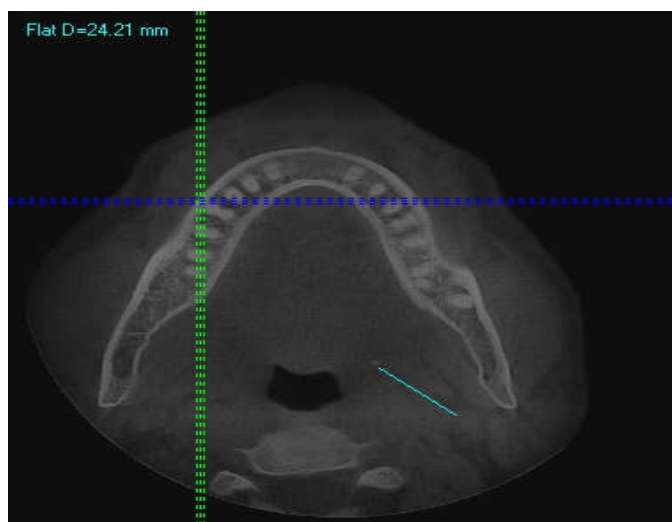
Transverse section for CBCT showing tonsilolith
